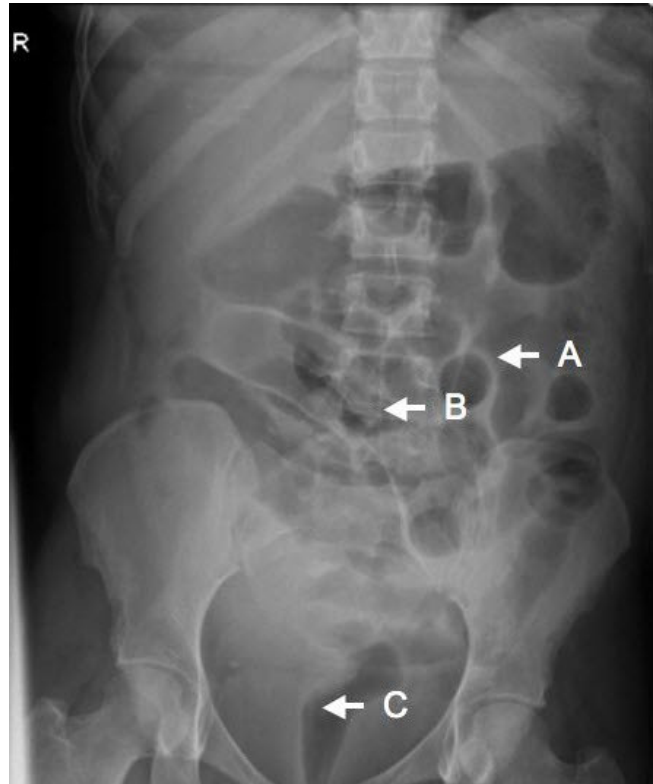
28 year old woman with postpartum pneumoperitoneum and peritonitis after water birth. Plain supine abdominal x-ray performed 4 days after delivery showing (A) mural oedema, (B) some prominent loops of small bowel centrally and (C) air in the rectum.
